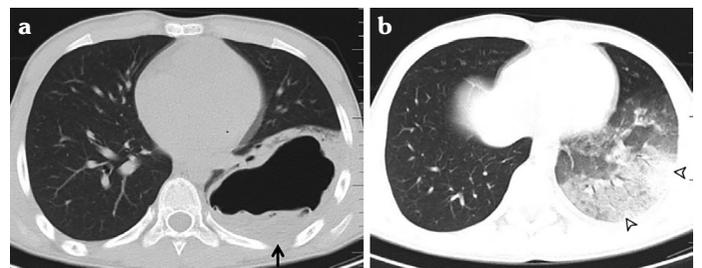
Whirl sign. Chest computed tomography images of a 15-year-old male patient with a ruptured hydatid cyst show (a) collapsed membranes (arrow) without fluid within the cyst in the lower left lobe and (b) inferior consolidation (arrowheads)
